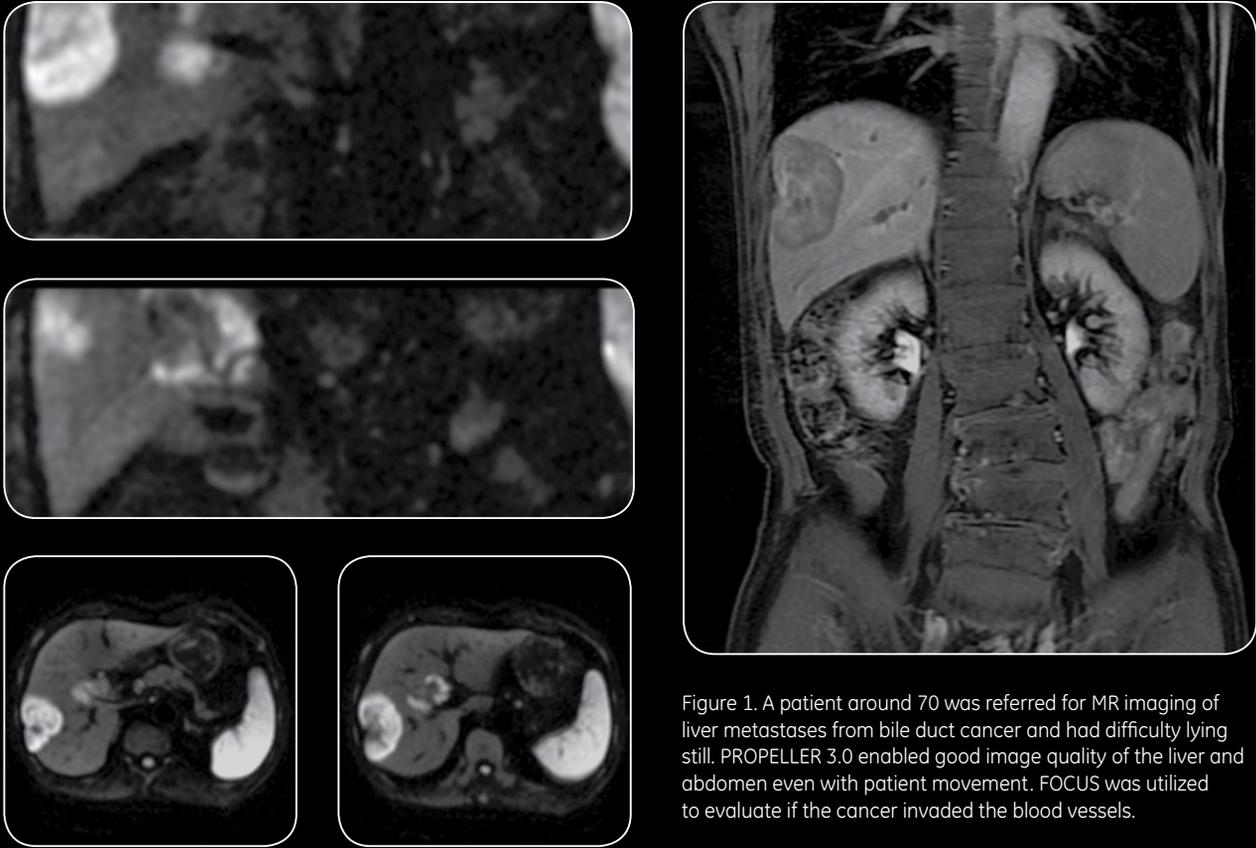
A patient around 70 was referred for MR imaging of liver metastases from bile duct cancer and had difficulty lying still. PROPELLER 3.0 enabled good image quality of the liver and abdomen even with patient movement. FOCUS was utilized to evaluate if the cancer invaded the blood vessels.
